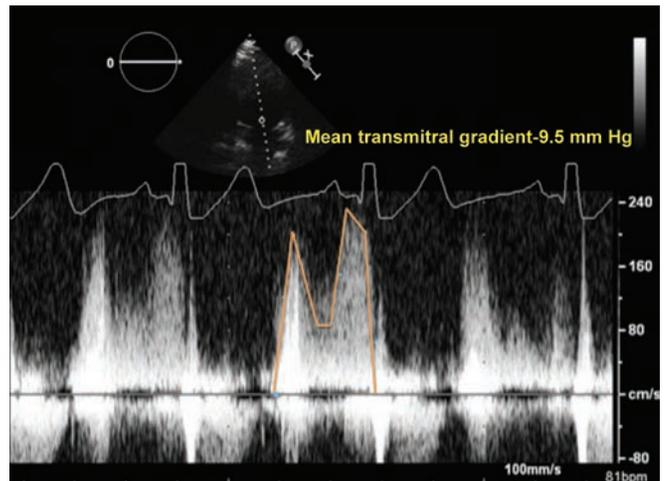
Continuous wave Doppler showing mean pressure gradient of 9.5 mm Hg through the mitral valve.
